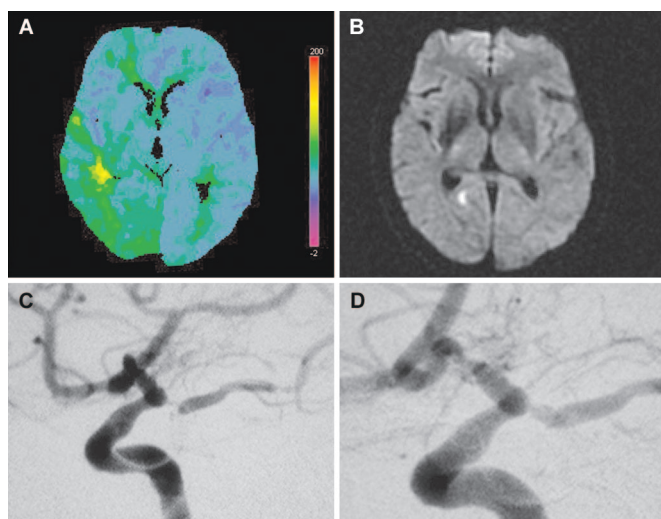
A, computed tomographic perfusion imaging obtained from a 72-year-old woman with a history of a 5-minute episode of unresponsiveness at home demonstrating significantly increased time to peak in the right posterior cerebral territory. B, diffusion-weighted magnetic resonance image scan obtained from the same patient demonstrating only a small area of infarction in the right posterior cerebral territory. C, diagnostic cerebral angiogram demonstrating a fetal posterior cerebral artery with more than 90% stenosis. D, postangioplasty cerebral angiogram demonstrating significantly increased lumen size of the posterior cerebral origin.
